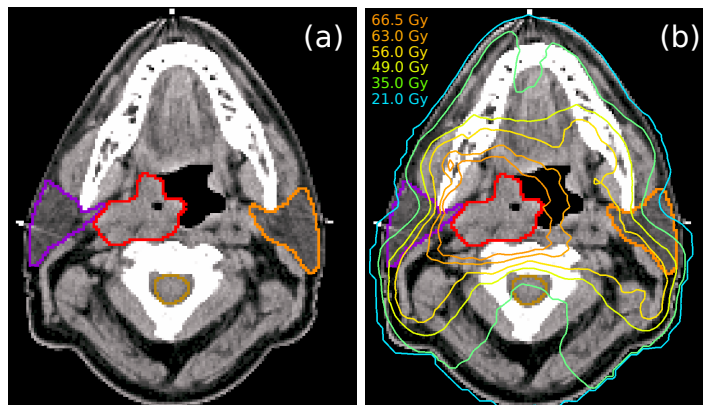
(a) Planning CT of a HNC patient with delineation of the gross tumor volume (GTV) (red) and OARs. OARs visible in this axial representation consist of left parotid gland (orange), right parotid gland (purple) and myelon (gold). Patient fixation in treatment position is obtained using thermoplastic masks. (b) Visualization of the planned total dose distribution for IMRT treatment of this patient by corresponding dose isocontours. A total dosis of 70 Gy was prescribed to the GTV. The dose sparing of the OARs can be appreciated.
